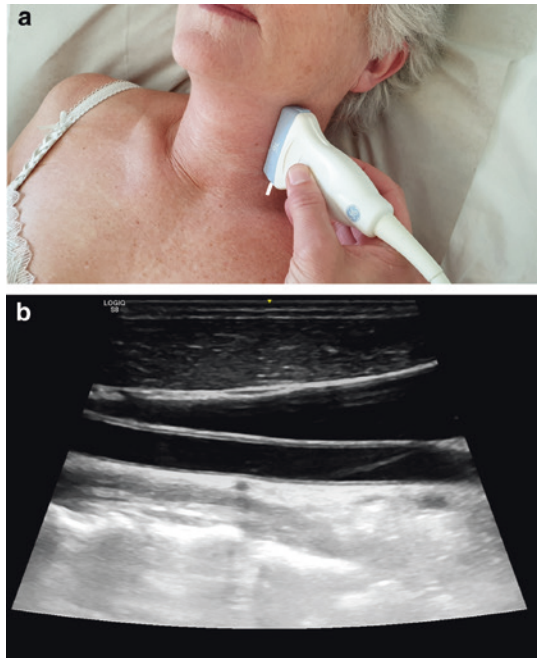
Examination of the carotid artery: a recommended transducer position, b ultrasonographic image, longitudinal view
